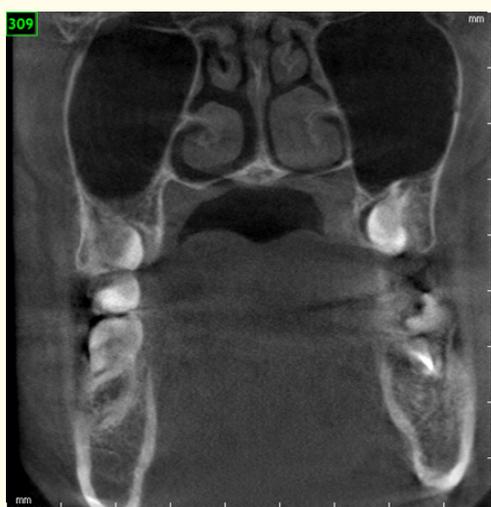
Dental cone beam computed tomography CBCT: coronal view.
